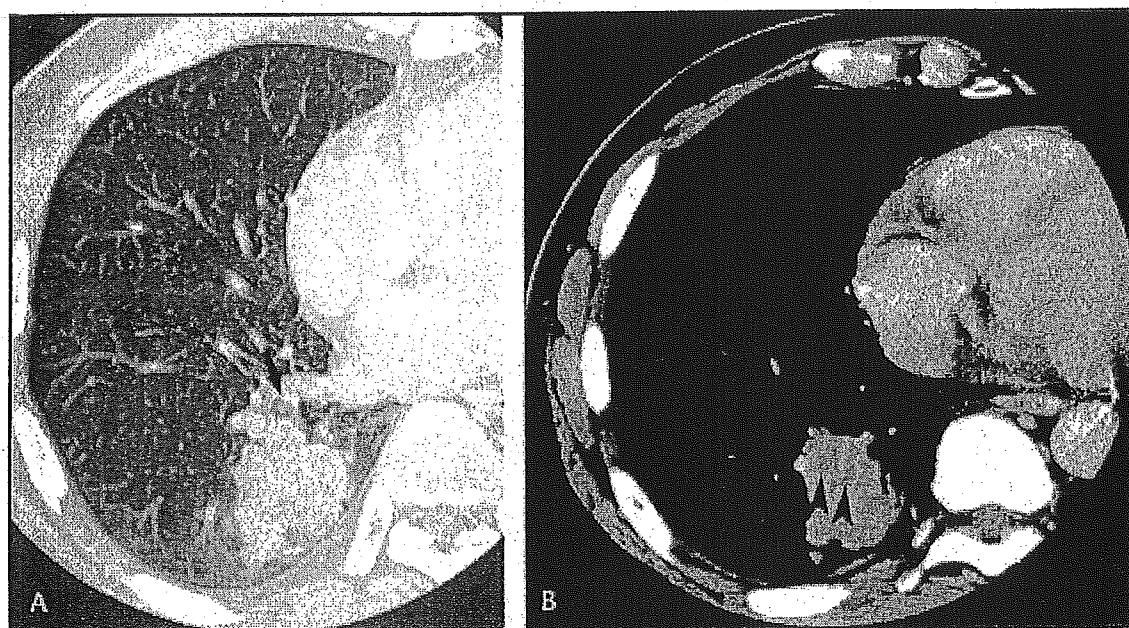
Mucin-producing adenocarcinoma of the lung in an 84-year-old man. A, Thin-section computed tomography image shows a poorly demarcated mass with mucus plugging (arrow). B, Thin-section CT image obtained 25 mm below the level of A shows tubular low attenuation of mucus plugging (arrowheads) in the lumen of a dilated peripheral bronchus in the mediastinal window setting.
